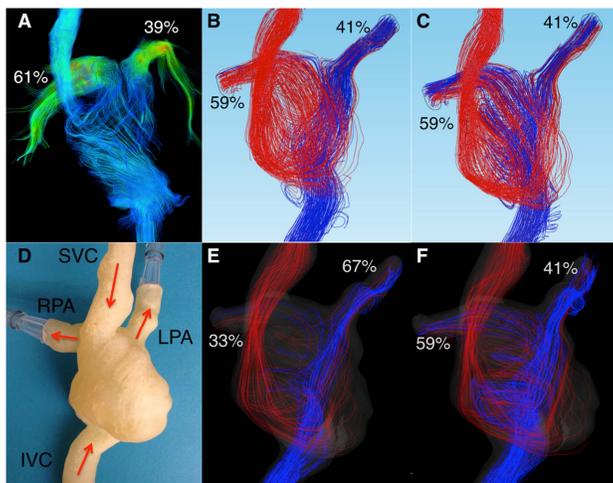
4D Flow MRI in a 30YO atrio-pulmonary TCPC patient compared to patient-specific physical and CFD models. A. *In vivo* velocity color-coded streamlines. B. *In silico* results at 3 L/min. C. *In silico* results at 4.5 L/min. D. Patient-specific physical model fabricated from MRI using SLS. E. *In vitro* results at 3 L/min. F. *In vitro* results at 4.5 L/min. For B, C, E and F, blue and red streamlines represent IVC and SVC flow, respectively. Flow into each PA is shown as percent of the total outflow.
